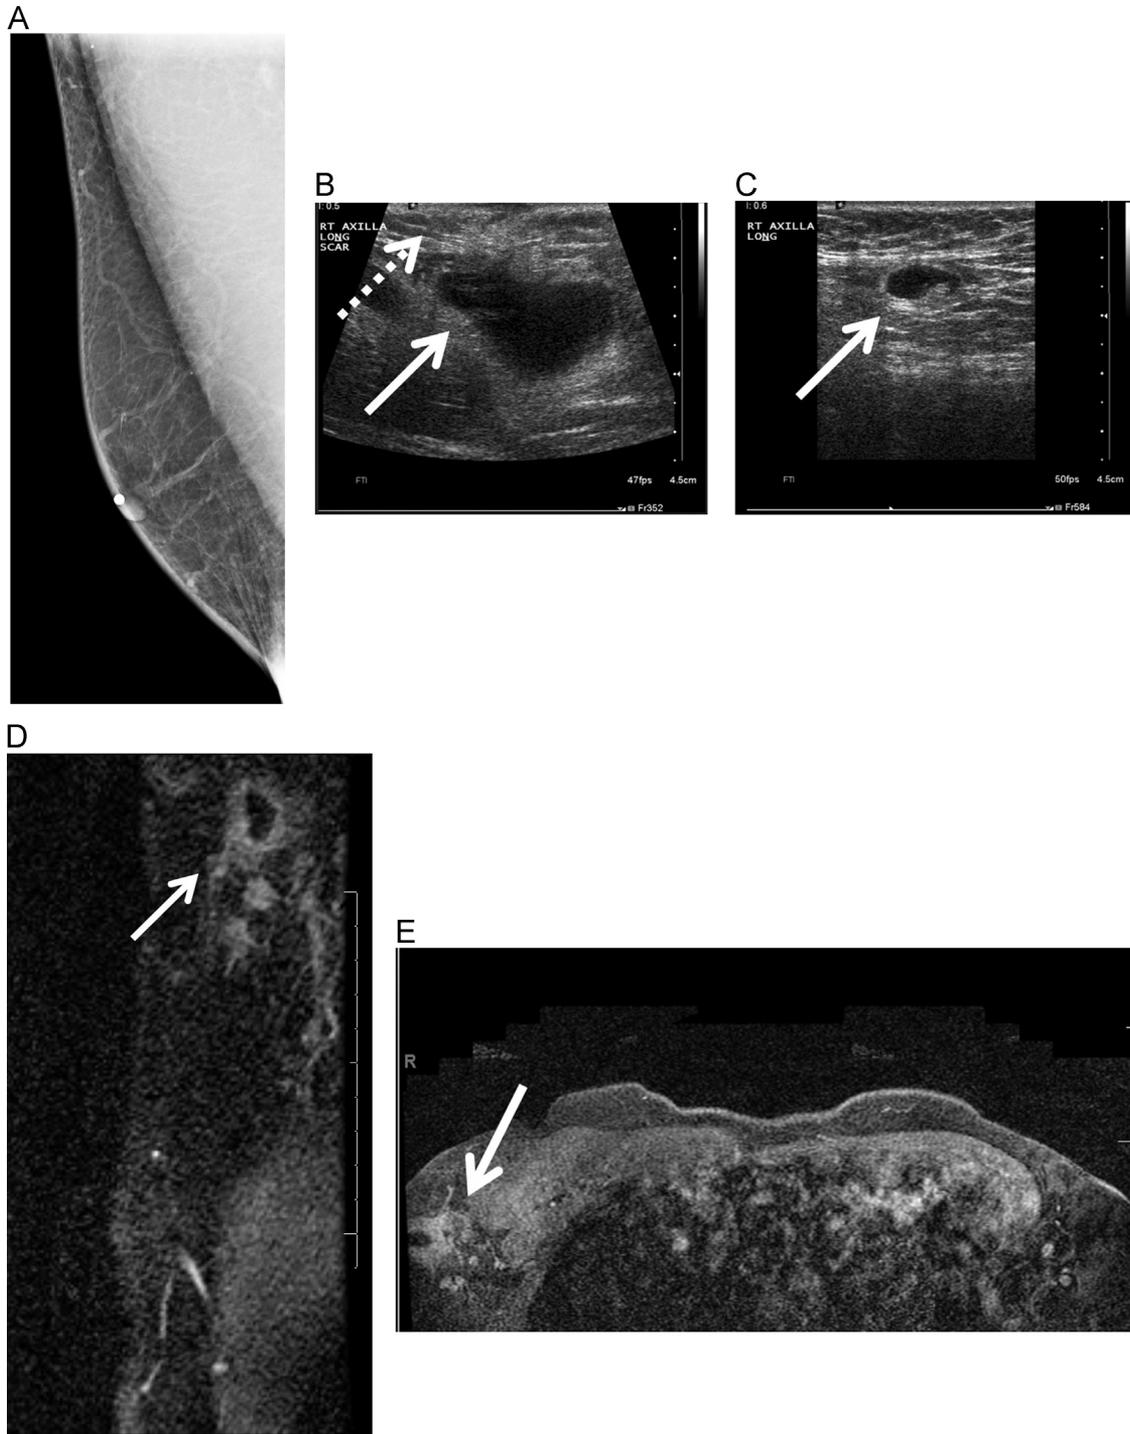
A 66-year-old male status postsurgical excisional biopsy of a right axillary mass yielding infiltrating ductal carcinoma involving the skin and the subcutaneous tissues had positive margins. Right MLO mammogram (A) does not show any abnormalities. The surgical site was out of field of view due to its superior location. US of the surgical site (B) demonstrates a postoperative seroma (solid arrow) and overlying skin thickening (dotted arrow). No suspicious abnormalities were seen. US of the right axilla (C) shows a suspicious lymph node with focal cortical thickening (arrow). FNA of the lymph node was benign. Sagittal and axial postcontrast T1-weighted images with fat suppression (D and E) demonstrate enhancing nodular thickening surrounding the postoperative seroma (arrows), corresponding to the positive margins seen at the time of the surgical excisional biopsy.
